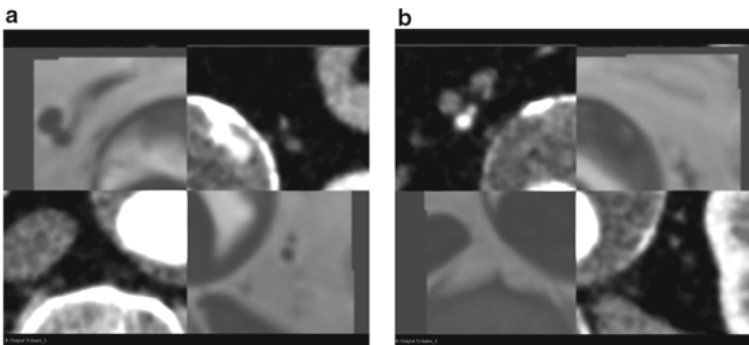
The registration of the CT and MRI dataset using 3D slicer a checkerboard with MRI top-left b checkerboard with CT top-left
